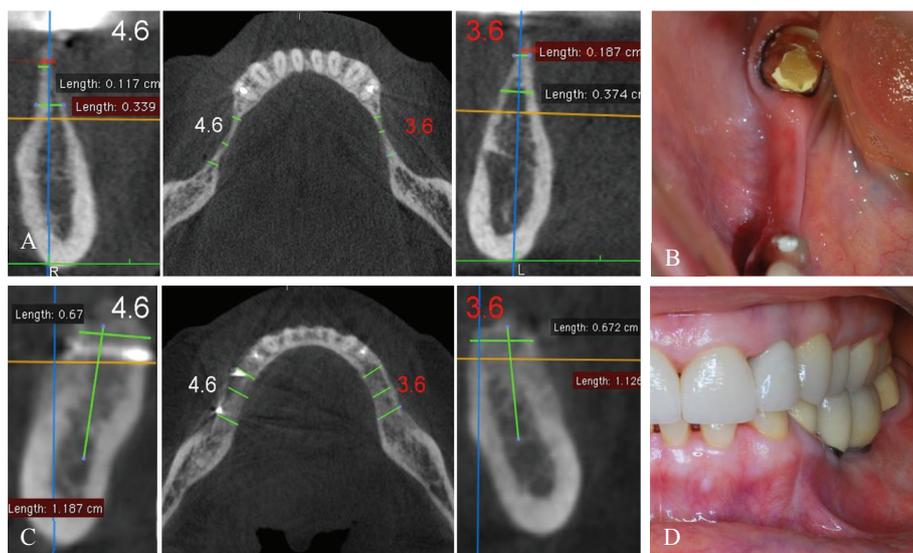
Stages of RS after lingual shift: A – The initial CBCT; B – Alveolar ridge in 3.5, 3.6, 3.7 teeth area; C – CBCT 4 month post Op; D – Prosthetic design 8 years after implantation and prosthetics
